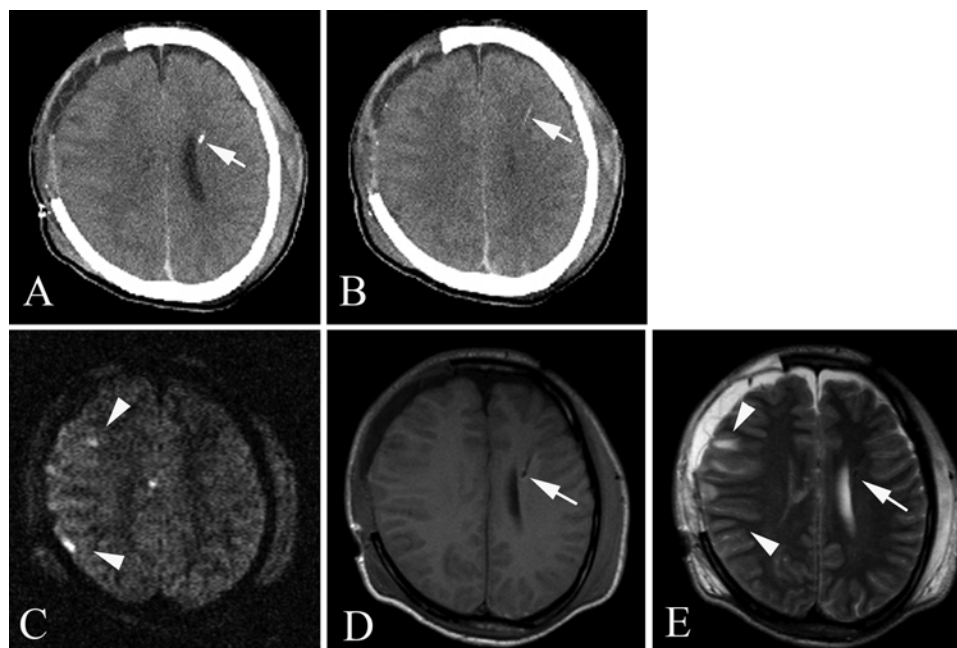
A and B: Axial CT images obtained on Day 5 after right temporal lobectomy and decompressive craniectomy demonstrating improvement of brain swelling. The ICP transducer tip (*white arrows*) is located in the left frontal lobe parenchyma near the frontal angle of the left lateral ventricle. C–E: Axial MR images obtained on Day 6, including diffusion-weighted (C), T1-weighted (D), and T2-weighted (E) sequences. The diffusion-weighted and T2-weighted images demonstrate contusions of the right temporoparietal lobe (*white arrowheads*) but no diffuse axonal injury. No contusions are demonstrated in the left cerebral hemisphere. The T1-weighted and T2-weighted images also demonstrate that the ICP transducer tip (*white arrows*) is located in the left frontal lobe parenchyma near the frontal angle of the left lateral ventricle.
